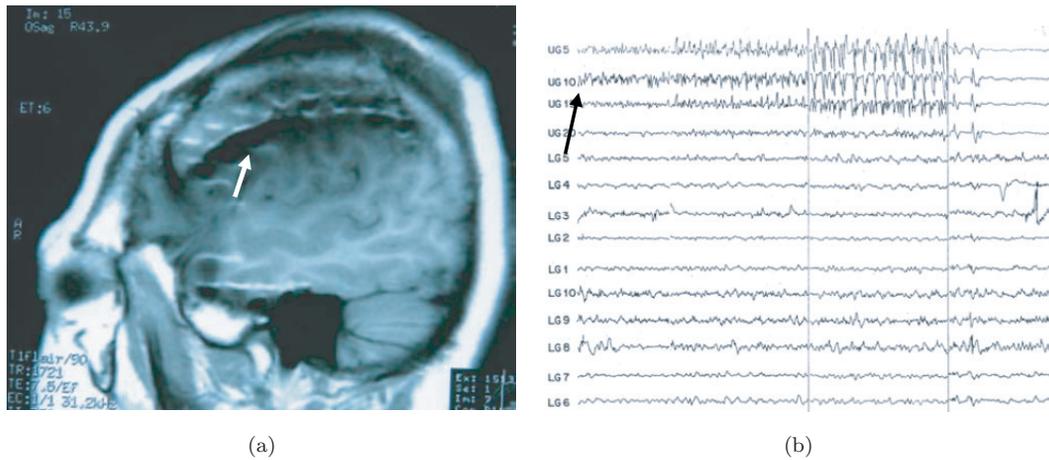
Case 2, patient with primary motor cortex seizures. 2(a) shows MRI with right 20 contact grid position; white arrow indicates contact UG10 where ictal activity initiated. 2(b) shows ictal recording, black arrow indicates seizure onset on contact UG10 (upper frontal grid). Vertical lines show where recording was cut, for space purposes.
